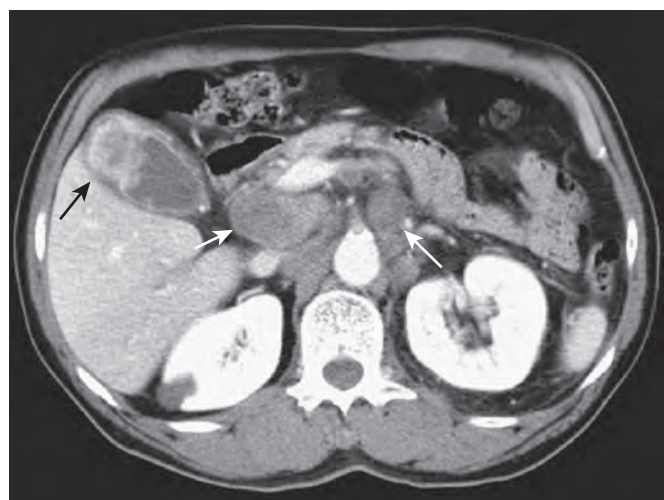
Polypoid gallbladder carcinoma with nodal metastasis. CT scan demonstrates a polypoid gallbladder carcinoma (black arrow) and low-density portocaval and para-aortic lymph nodes containing metastases (white arrows).
